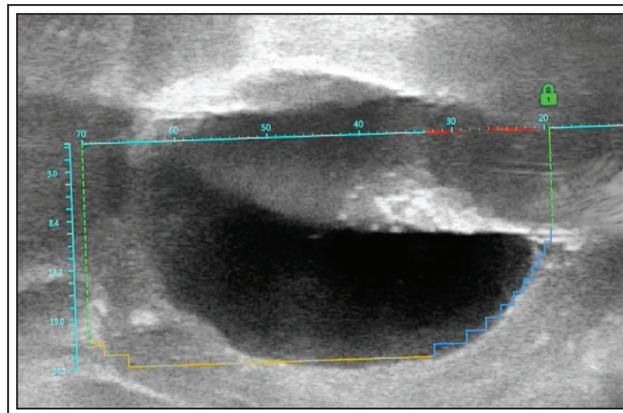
Transrectal ultrasound image of balloon catheter in prostatic fossa following Aquablation.
